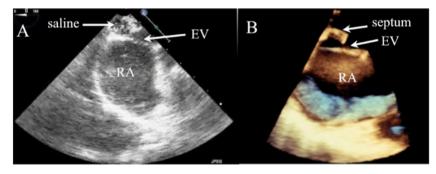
Panel A: Transoesophageal echocardiography showing saline contrast injection (saline) posterior to Eustachian valve (EV); RA=right atrium. Panel B: three dimensional transoesophageal echocardiography showing the anterior Eustachian valve (EV) separately from true septum (septum) which is posterior; RA=right atrium.
